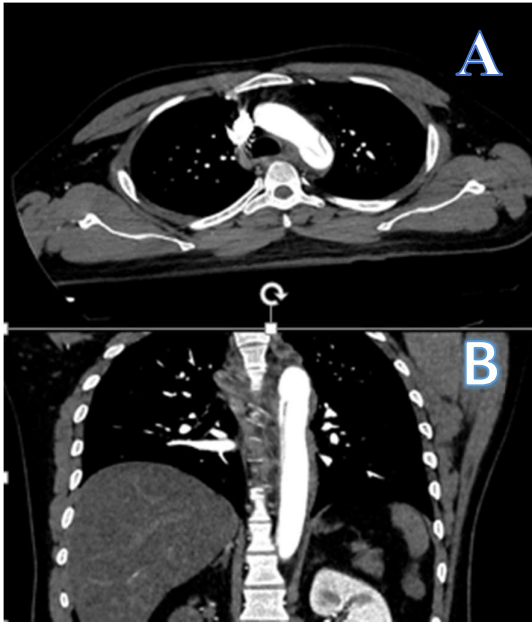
shows Axial Contrast CT image of a intimal flap causing double lumen appearance in the arch of aorta. 2B showing Coronal view of intimal flap is seen extending to the descending thoracic aorta.
